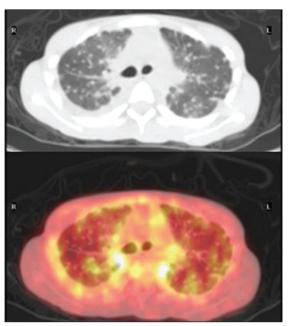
The transaxial non enhanced CT of the chest and the fused FDG PET/CT show multiple bilateral pulmonary nodules that vary in size and metabolic activity.
